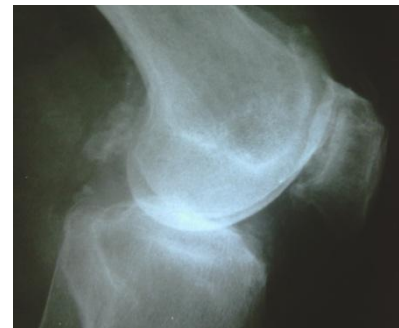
X-ray of knee (lateral view) showing severe osteoarthritis and loose bodies
